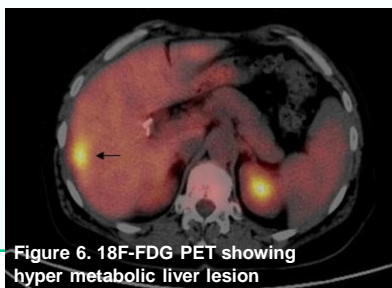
18F-FDG PET showing hyper metabolic liver lesion
